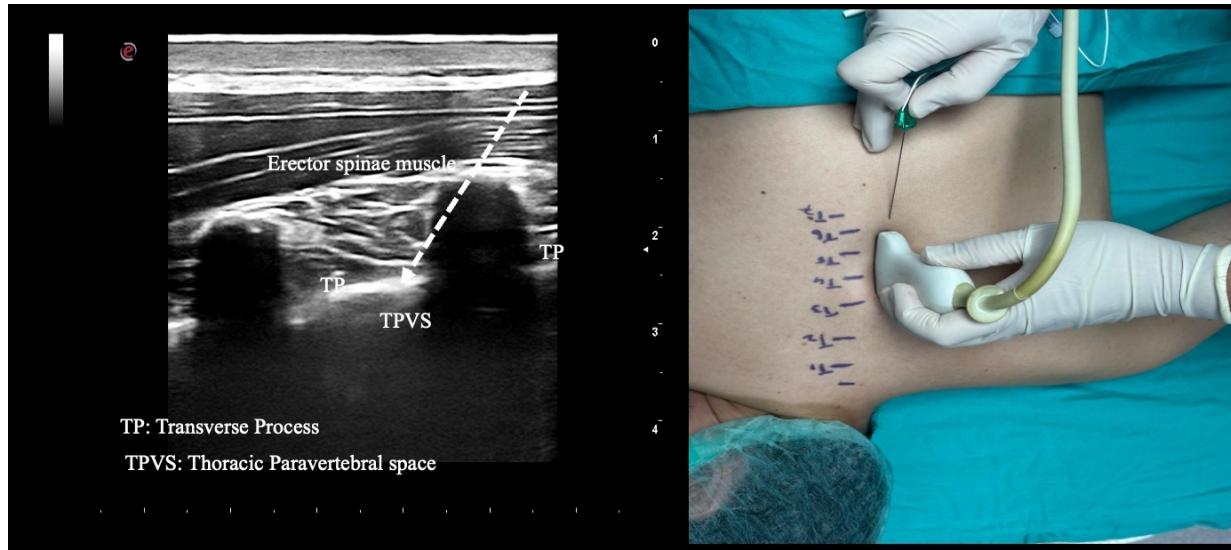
Application of the TPVB and an ultrasound image.
